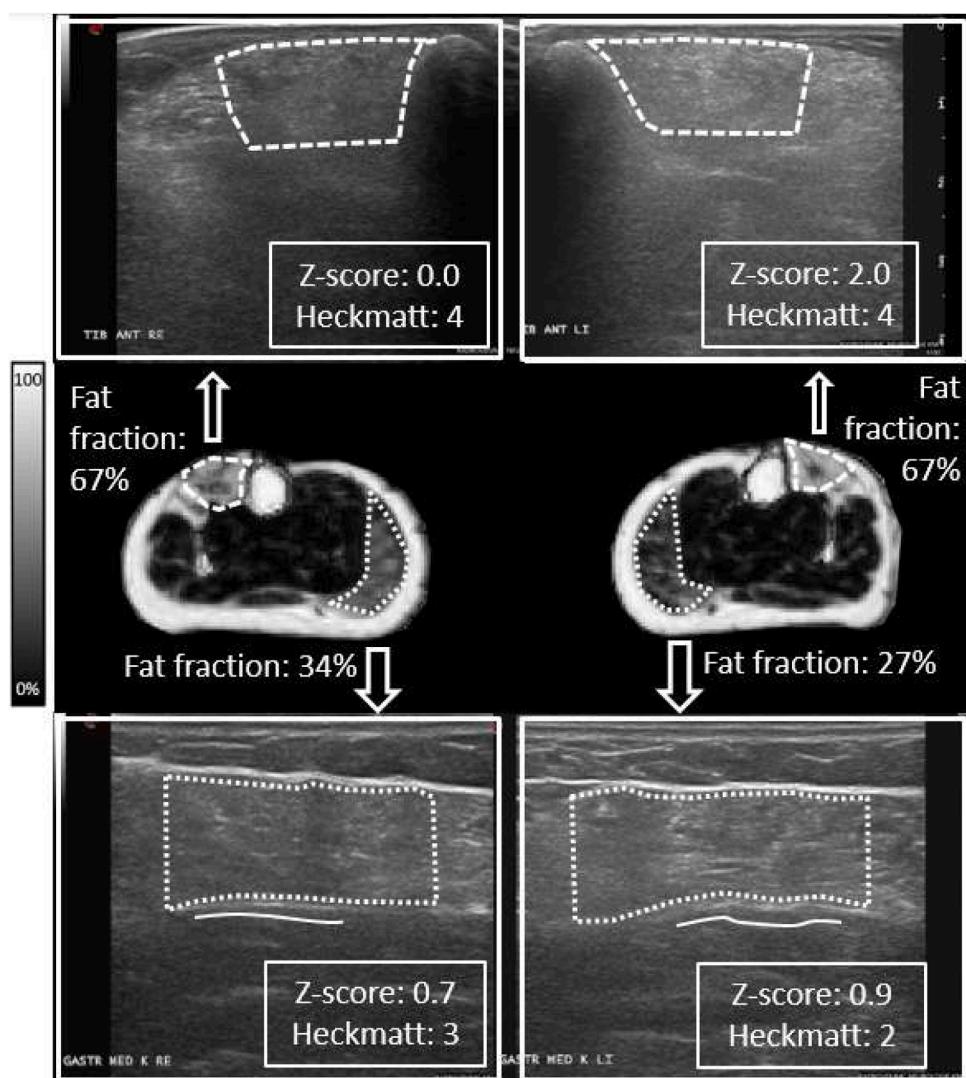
Heckmatt and z-score echogenicity discrepancy versus MRI Dixon fat fraction in lower leg muscles of an FSHD patient.
